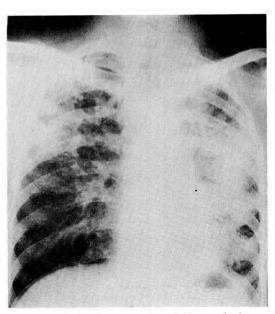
b. Transient worsening of X-ray shadows after intensive chemotherapy.
